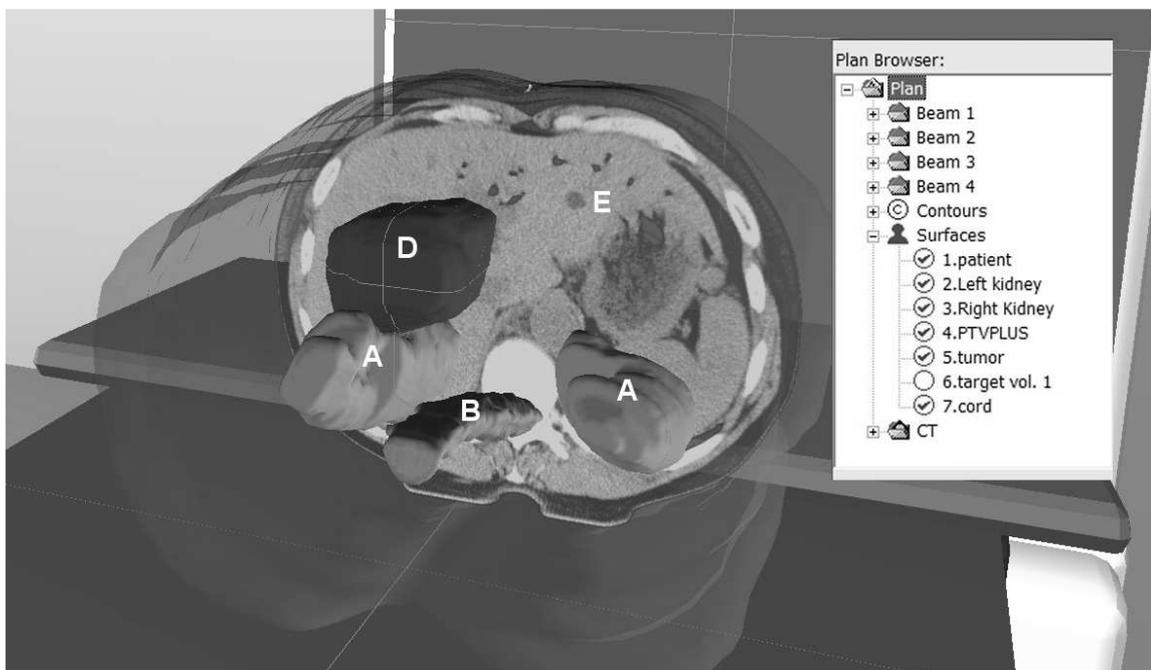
Visualization showing patient anatomy on couch of radiotherapy treatment room. View shows tumour (D) being treated, organs at risks (A – kidneys, B – spinal cord) where dose must be below a specified level, (E) CT slice clipped to patient's skin surface. Inset is the dialogue box showing elements of the treatment plan.
